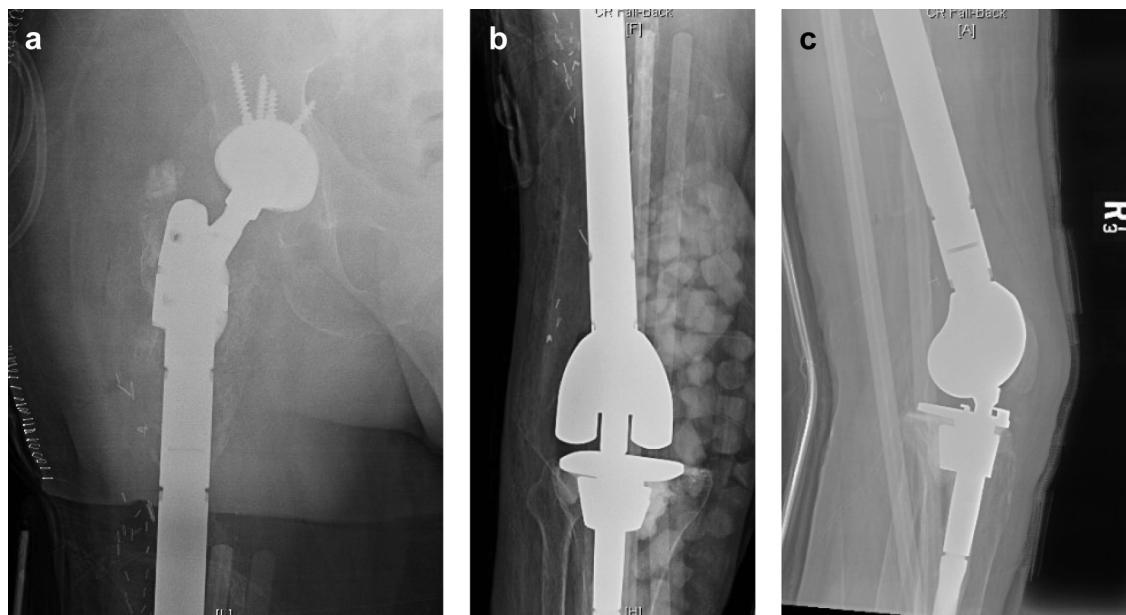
Postoperative AP (a and b) and lateral (c) radiographs following second-stage reimplantation of the total femur arthroplasty in patient 2. AP, anteroposterior.
